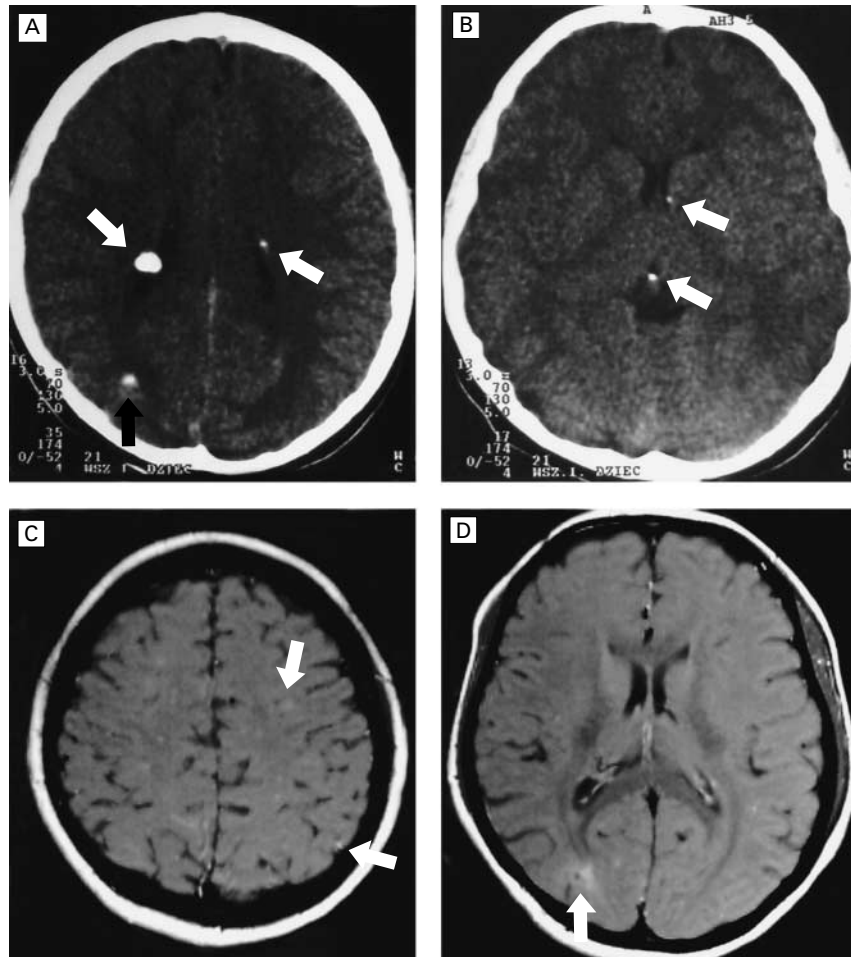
Computed Tomographic and Magnetic Resonance Imaging Scans of the Brain in a Patient with Tuberous Sclerosis.
